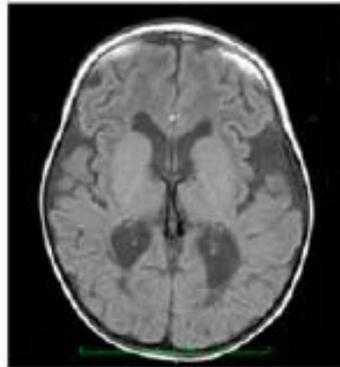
Stabilization of brain atrophy in younger patients after gene therapy. Representative MRI images from Canavan disease patient 01-118-08 after AAV2-ASPA gene therapy. The MRI images of this younger subject, who did not have brain mass loss before gene therapy and was classified as a better responder, reveal stabilization of hydrocephalus in the frontal horn region (white arrow) and third ventricle (black arrow), as well as retention of brain mass in the frontal and posterior parietal regions.
